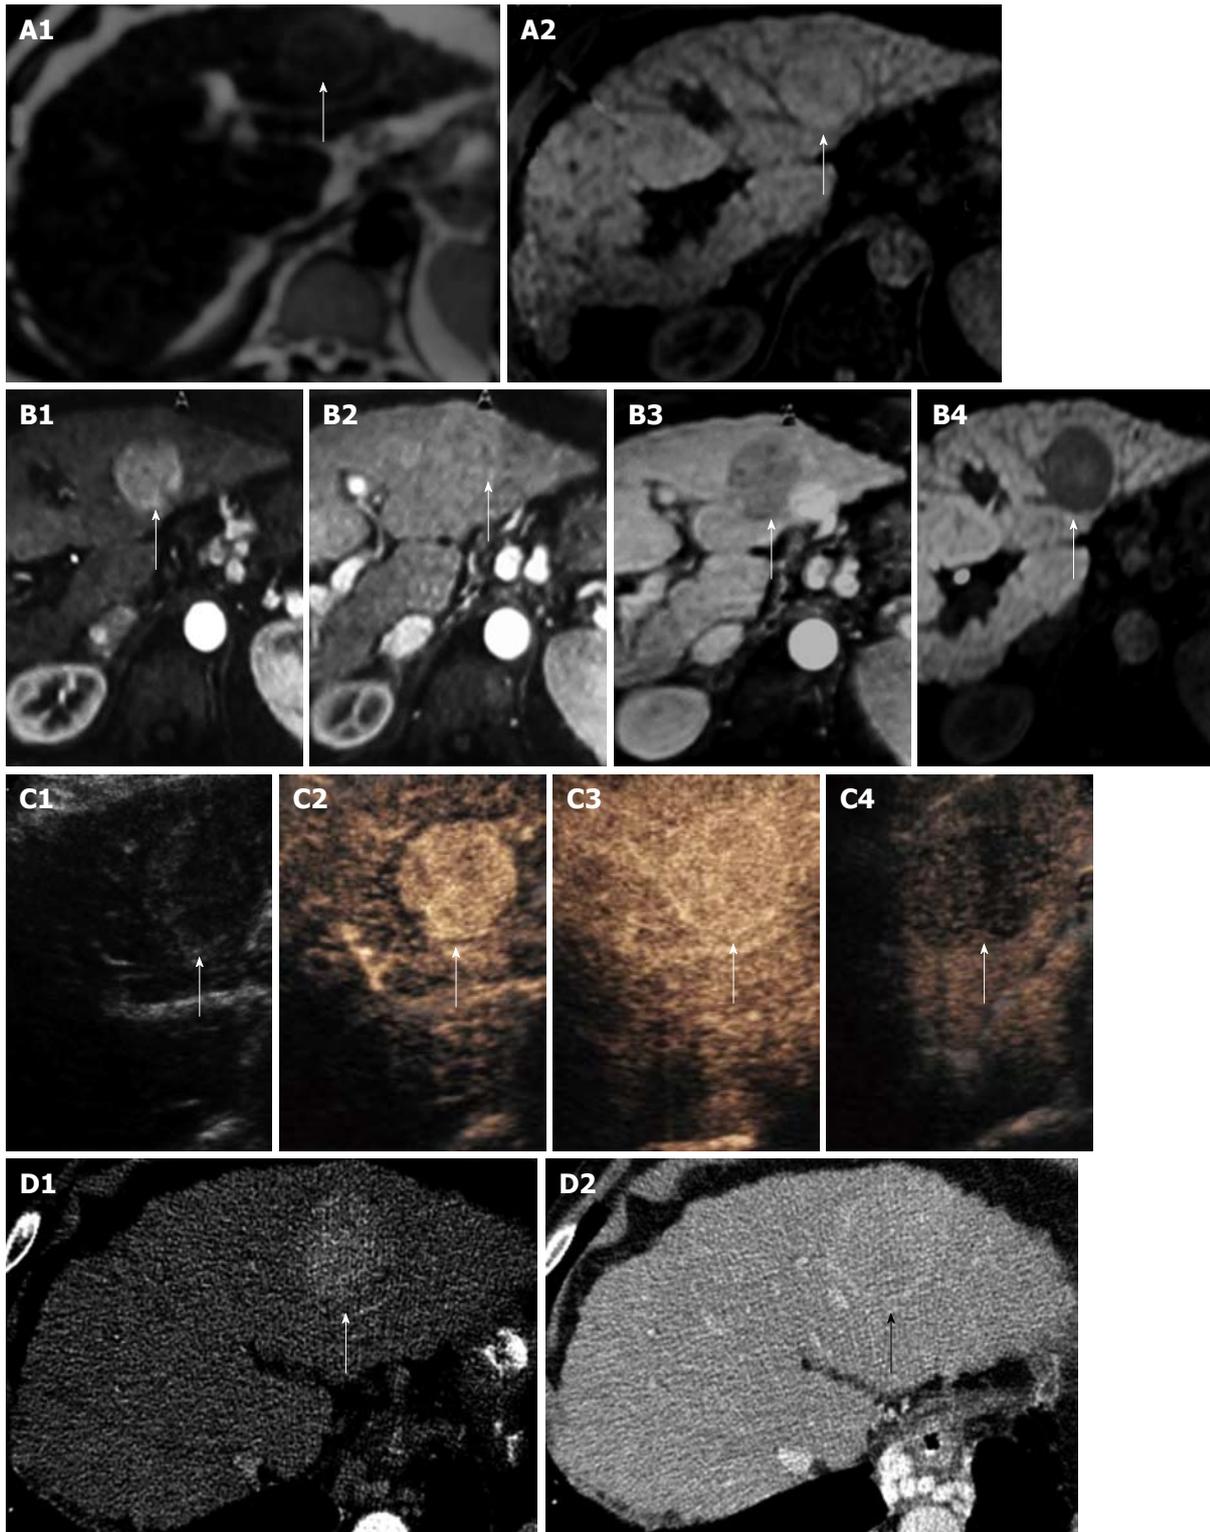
There is a large HCC in the left lobe of the liver with a pseudocapsule, hyper-enhancing on arterial phase and showing washout on late phases on MR and CEUS and is iso-intense in portal phases on CT and CEUS. The pseudo-capsule enhances in the portal phase on all modalities. A1: T2 weighted scan showing slightly higher intensity HCC (arrow); A2: T1 weighted scan shows same HCC which is iso-intense (arrow); B1: MultiHance enhanced T1 weighted scan in the arterial phase showing enhancement of the HCC (arrow); B2: MultiHance enhanced T1 weighted scan in the portal phase showing iso-enhancement of the HCC (arrow); B3: MultiHance enhanced T1 weighted scan at 2 min showing contrast wash-out in the HCC (arrow); B4: MultiHance enhanced T1 weighted scan at 40 min showing hypointense HCC (arrow); C1: Baseline ultrasound shows iso-echoic HCC (arrow); C2: SonoVue enhanced ultrasound shows hyper-enhancing HCC (arrow) in the arterial phase; C3: SonoVue enhanced ultrasound shows iso-enhancing HCC (arrow) in the portal phase with enhancement of the pseudocapsule; C4: SonoVue enhanced ultrasound shows wash-out of the HCC (arrow) in the late phase; D1: Contrast enhanced CT scan shows enhancement of the HCC (arrow) in the arterial phase; D2: Contrast enhanced CT scan shows iso-enhancement of the HCC (arrow) in the portal phase with enhancement of the pseudocapsule.
